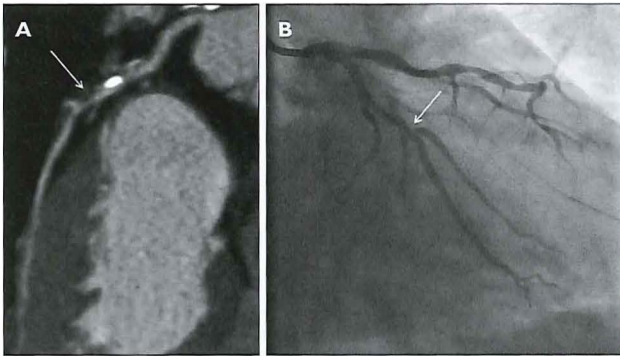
54-year-old man with hypercholesterolemia and stable angina. Curved multiplanar reformat of the circumflex coronary artery from CT coronary angiography (dual source CT scanner) shows an intermediate coronary stenosis (arrow) due to a non calcified plaque (A) confirmed by conventional coronary angiography (B). The coronary artery lesion was determined not to be hemodynamically significant at FFR measurement (FFR of 0.92).
